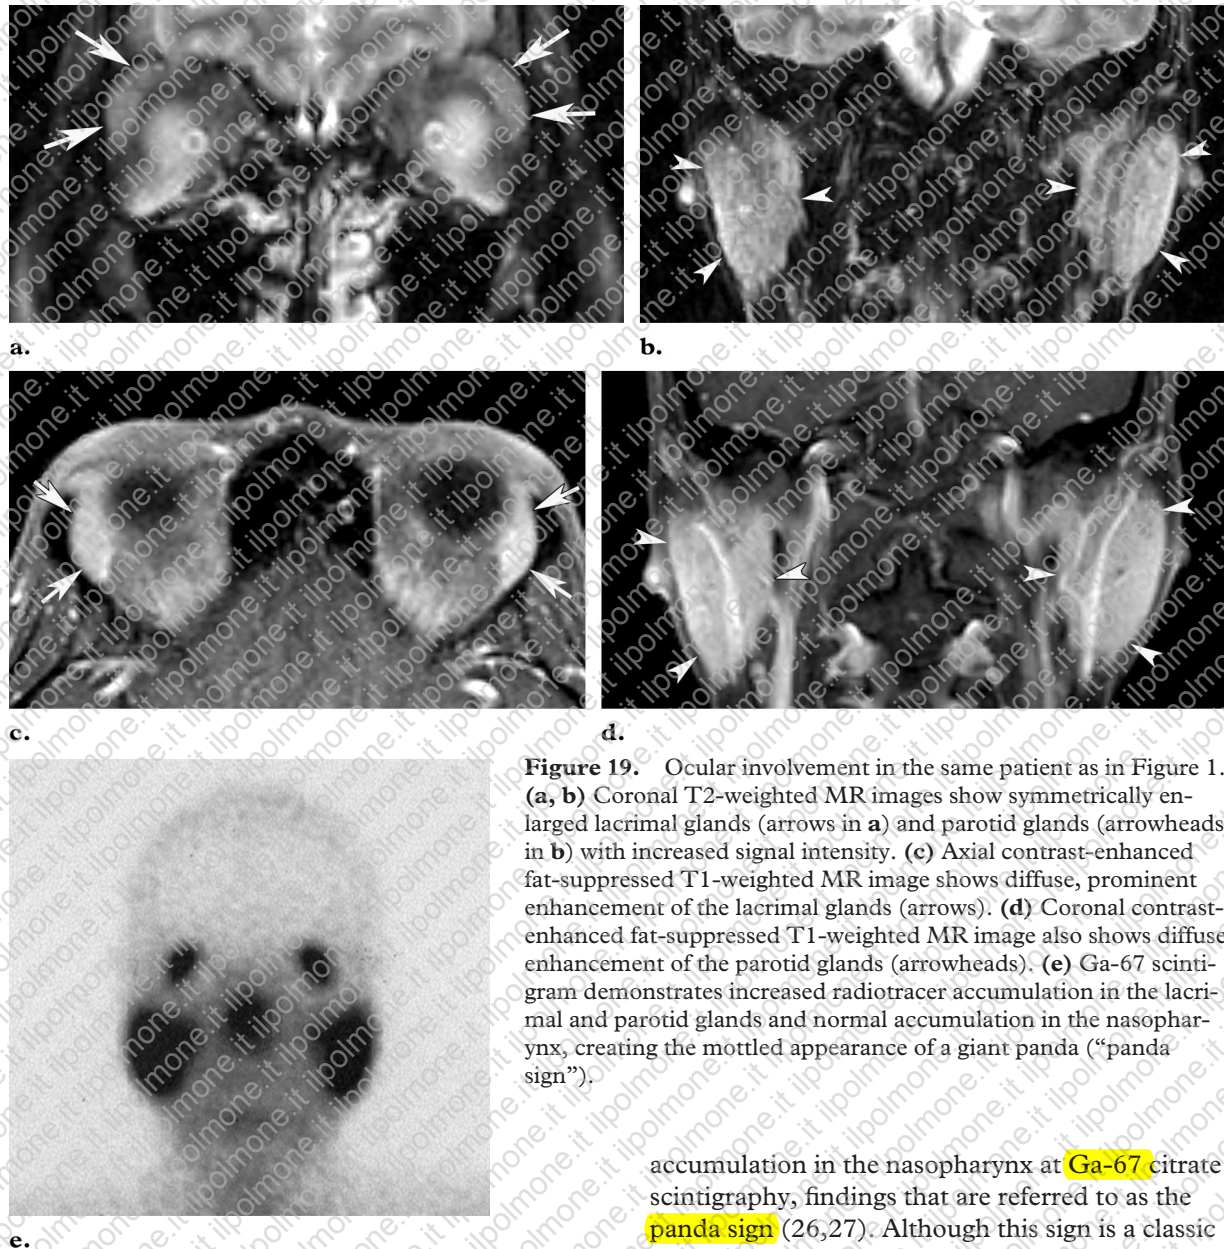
Ocular involvement in the same patient as in Figure 1. (a, b) Coronal T2-weighted MR images show symmetrically enlarged lacrimal glands (arrows in a) and parotid glands (arrowheads in b) with increased signal intensity. (c) Axial contrast-enhanced fat-suppressed T1-weighted MR image shows diffuse, prominent enhancement of the lacrimal glands (arrows). (d) Coronal contrast-enhanced fat-suppressed T1-weighted MR image also shows diffuse enhancement of the parotid glands (arrowheads). (e) Ga-67 scintigram demonstrates increased radiotracer accumulation in the lacrimal and parotid glands and normal accumulation in the nasopharynx, creating the mottled appearance of a giant panda (“panda sign”).
